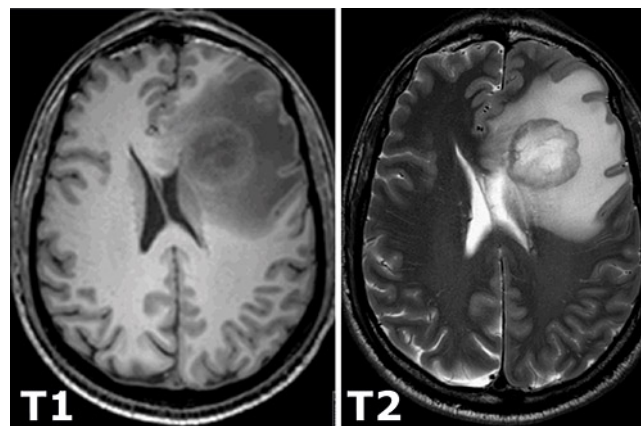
Example of a T1 vs a T2 sequence MRI [30]
